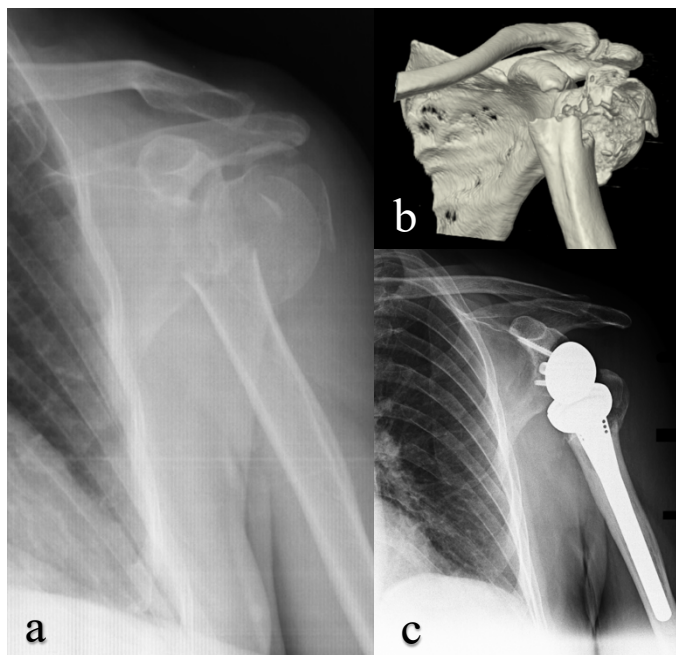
Pre-operative anterior posterior shoulder radiography (a) three-dimensional reconstruction computerized tomography image (b) and postoperative 4th month control anterior posterior radiography (c) with the diagnosis of multi-fragmentary proximal humeral fracture
